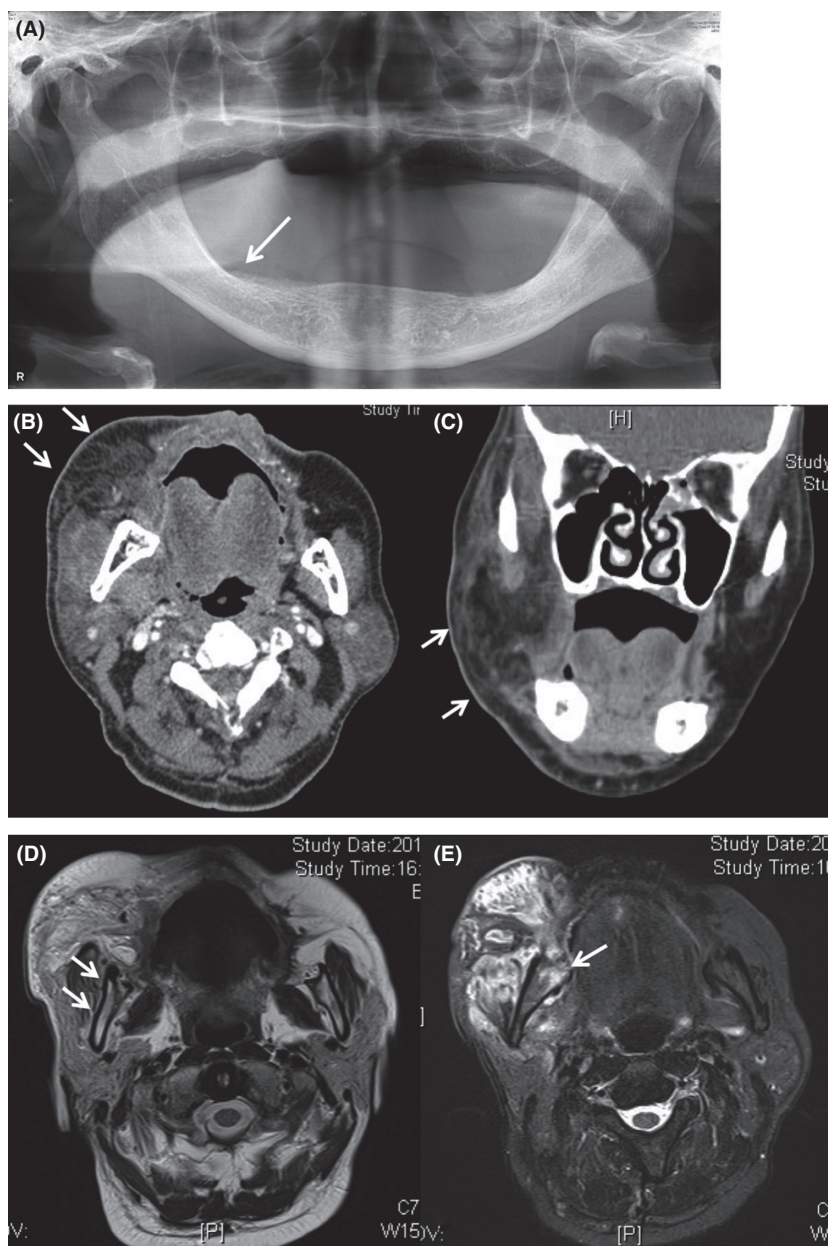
(A) No bone resorption is present on the right part of the mandibula in orthopantomogram analysis. (B, C) Right buccal swelling is apparent, but there is no bone resorption of the mandibula, based on computer tomography (CT) analysis. (D, E) Abnormal signal (i.e., a low signal on T1-weighted imaging [T1WI] and a high signal on T2-weighted imaging [T2WI]) of the bone marrow on the right angle part of the mandibula.
